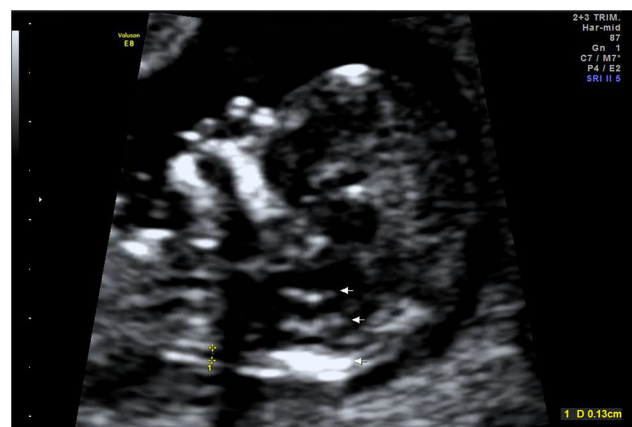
Ultrasound image showing three echogenic parallel lines in the posterior brain (arrows)
